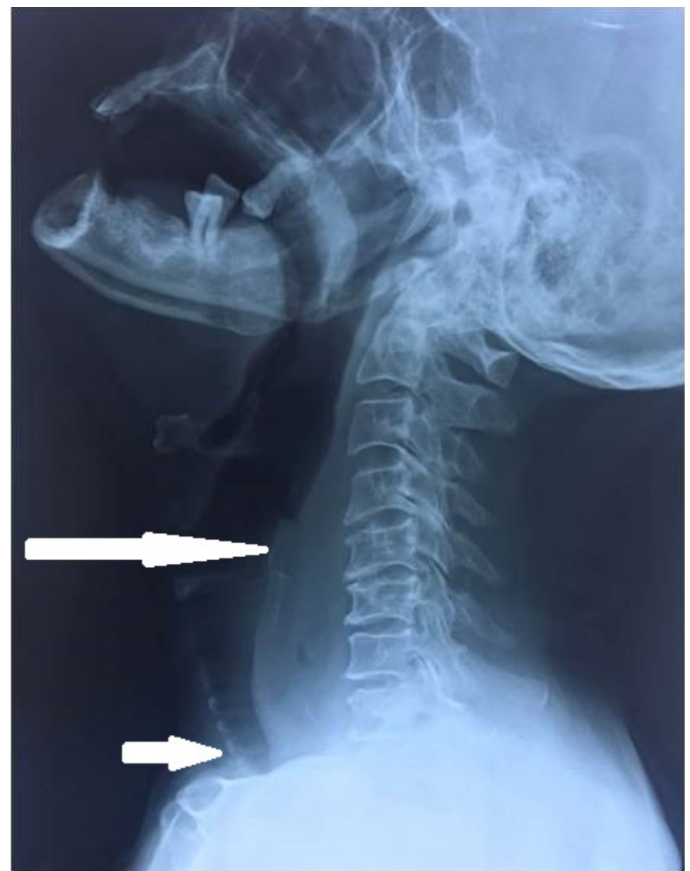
Lateral radiograph of the neck showing increased prevertebral space (big arrow), loss of cervical lordosis and mild tracheal compression (small arrow)
